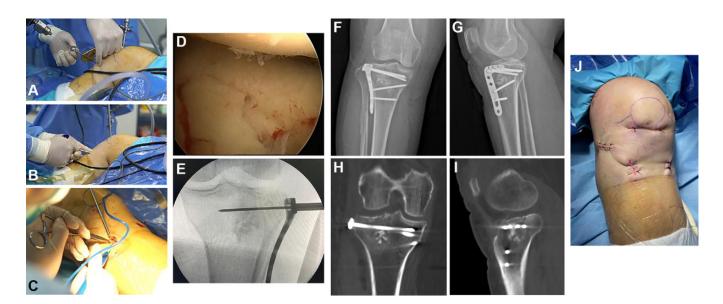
(A) A guide pin was inserted into the center of the lateral platform fracture. (B) The special reduction device elevated the depressed lateral plateau. (C) The locking compression plate was placed on the lateral side for fixation by MIPPO. (D) Arthroscopic examination revealed that anatomical reduction of the depressed fracture and the articular surface was flat. (E) Intraoperative fluoroscopy confirmed plate placement and articular surface restoration. (F and G) Postoperative radiographs and (H and I) CT showed a good anatomical reduction of the depressed lateral condyle in the tibial plateau fracture. (J) View of the knee after surgery. CT, computed tomography; MIPPO, minimally invasive percutaneous plate fixation.
